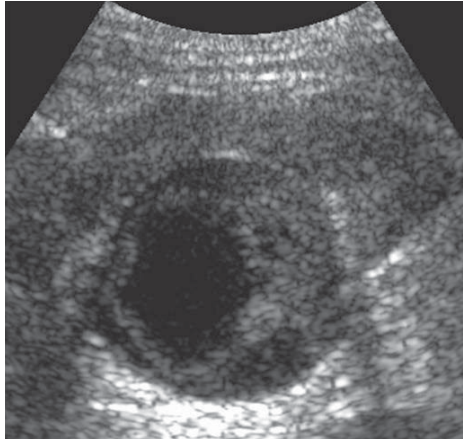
Ultrasonography. Renal cell carcinoma. Solid lesion with heterogeneous structure resulting from necrotic cystic elements
